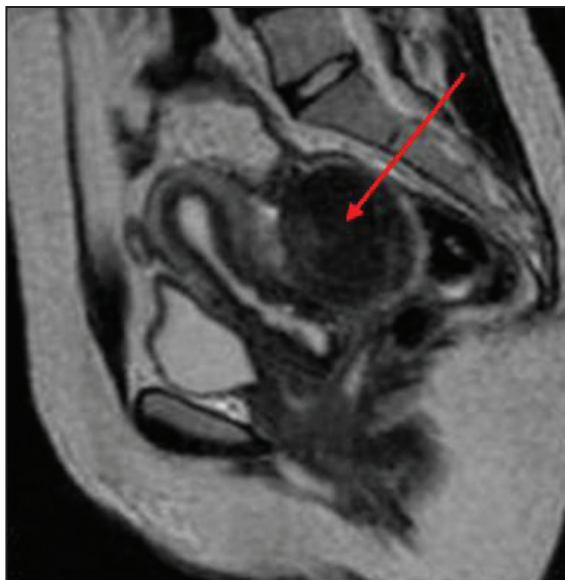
MRI is an excellent diagnostic tool. This MRI shows a posterior subserosal uterine fibroid.
